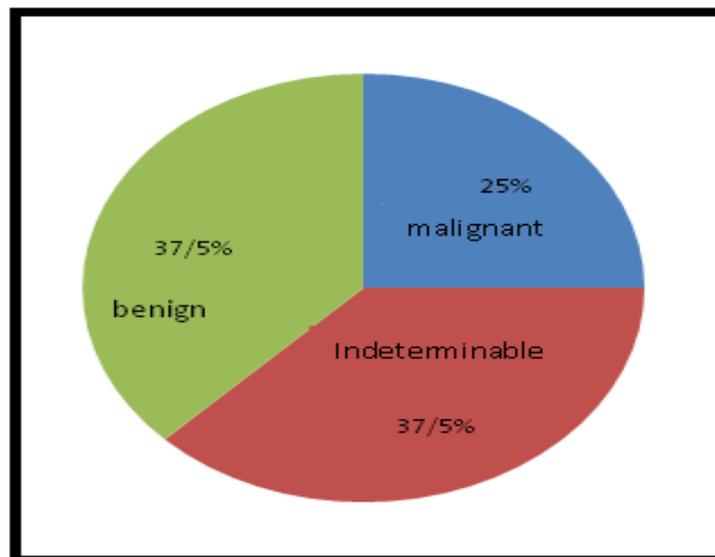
Patients' sonography results.
